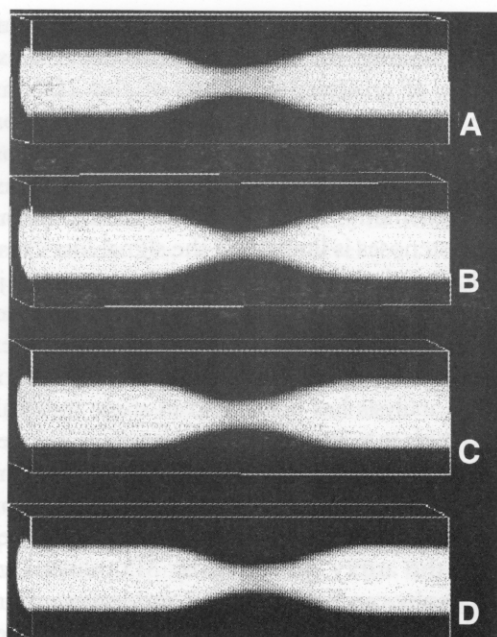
Three-dimensional power Doppler angiograms of the central stenosis with an 80% area reduction generated with a steady flow of 10 ml/sec. A, Without proximal and distal stenoses. B, With a 70% proximal stenosis. C, With a 70% distal stenosis. D, With proximal and distal stenoses of 70%.
